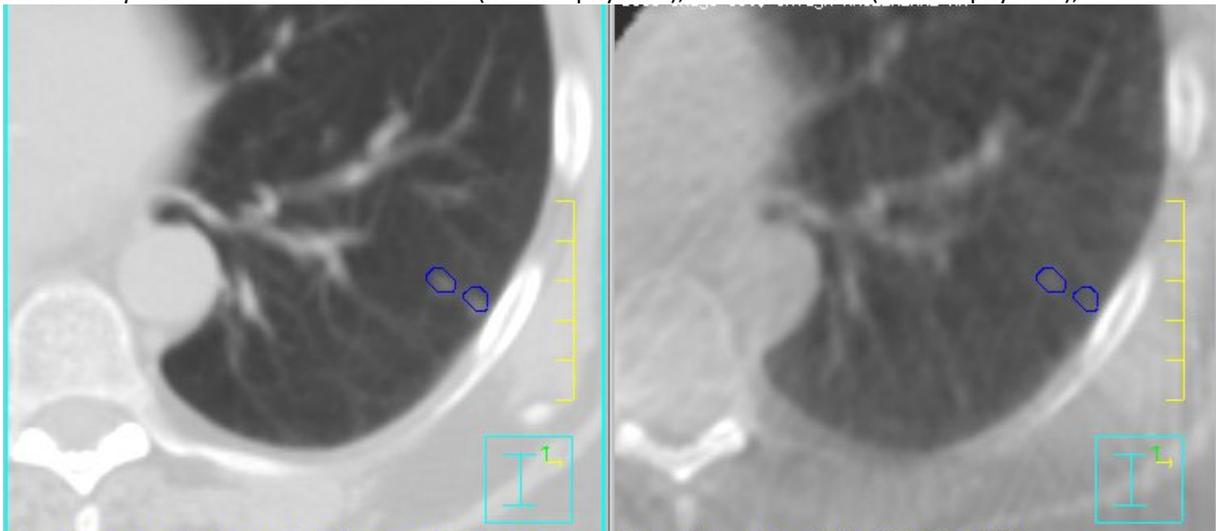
example of an axial image through the lungs showing 2 lung cancer nodules on CT (left) and on Cone-beam CT (right). Note the poor image quality of the Cone-beam CT.
